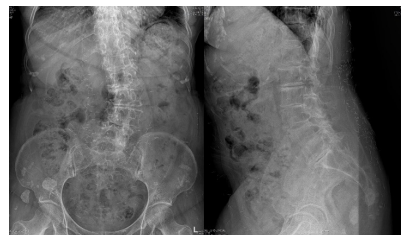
Lumbar spine X-ray scan.
